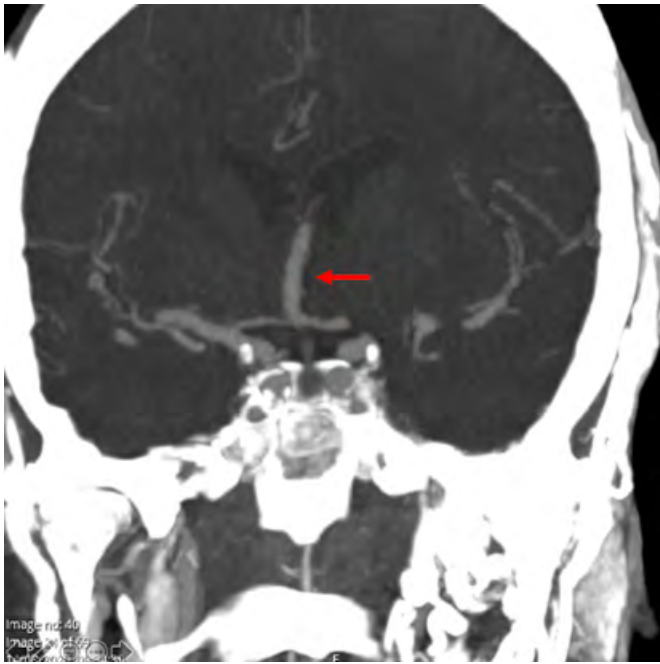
CT Angiogram, coronal view. Type 1 Azygos anterior cerebral artery (red arrow).
